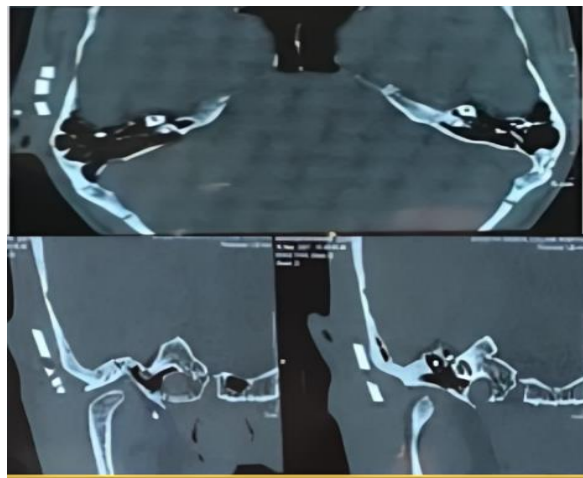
HRCT temporal bone showing radio-opaque foreign body.
